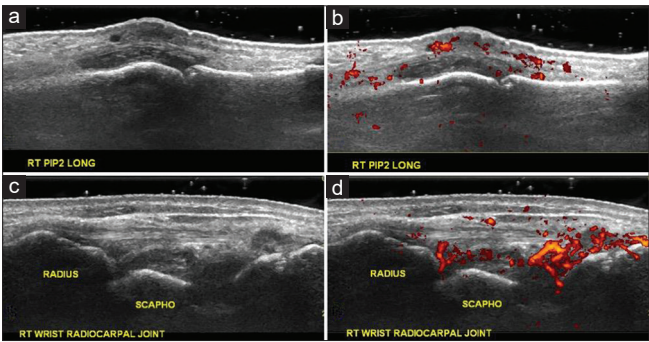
(a) (Grayscale) and (b) (Doppler signal) were right PIP2 rheumatoid synovitis, as Grade 2 by EULAR-OMERACT score; (c) (Gray scale) and (d) (Doppler signal) were right radio-scaphoid rheumatoid synovitis, as Grade 3 by EULAR-OMERACT score. EULAR: European League against Rheumatism
